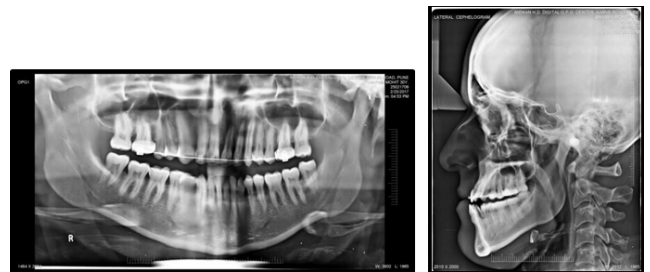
MID treatment radiographs
